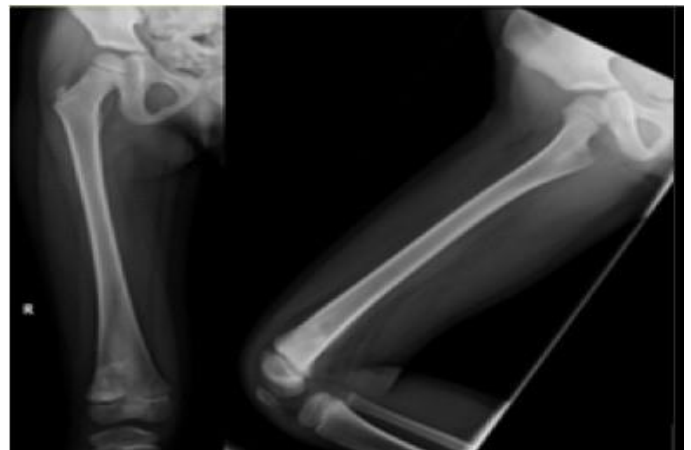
Anteroposterior and lateral radiographs of the right femur showing an expansive osteoblastic lesion in the distal metaphysis with cortical thinning and periosteal elevation
